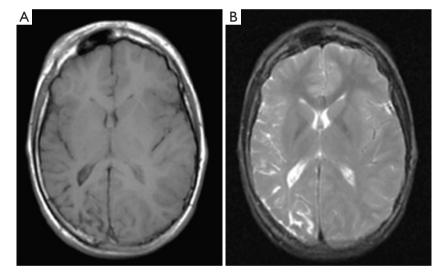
Patient 1 [as reported in reference (12): at his most recent follow-up] T1- (A) and T2- (B) weighted magnetic resonance images of the brain showing hyperpneumatisation of the right frontal sinus, atrophic right hemisphere and hypertrophic left hemisphere with cortical dysplasia (B).
